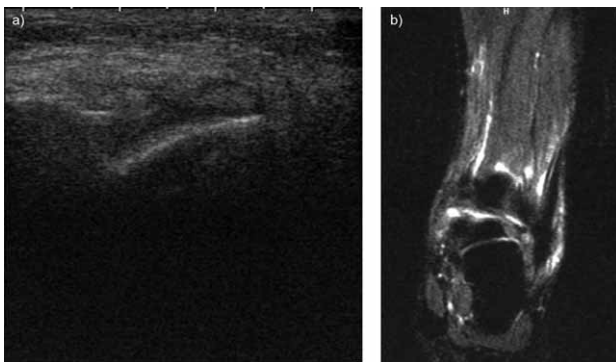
a) (Ultrasound) Stretching (Lesion G1) of the right Long flexor of the great toe muscle tendon; 3.b) (Magnetic resonance) Stretching (Lesion G1) of the left Long flexor of the great toe muscle tendon.
